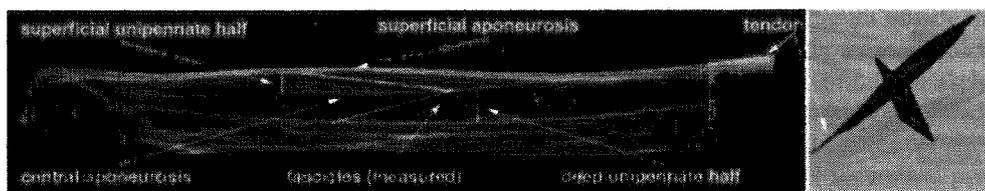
Longitudinal ultrasound image and polygonal boundary of the human TA.
